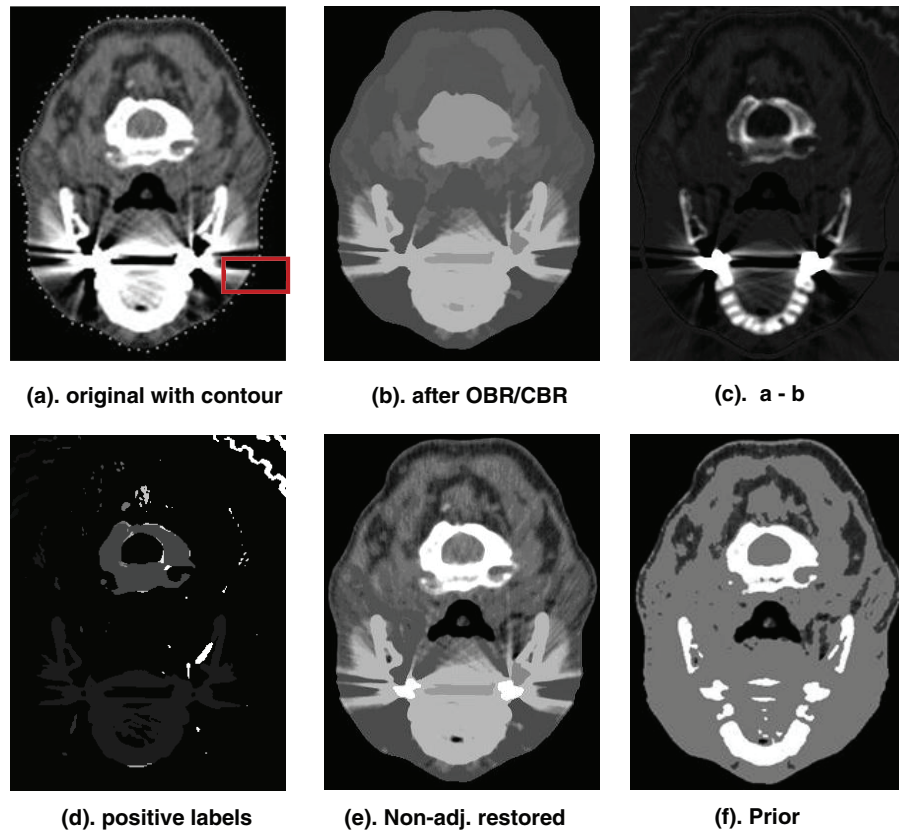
Stages in the generation of a prior image of a CT head scan. The contour is represented by the dotted line in (a), the image after CBR and OBR in (b), the difference image (a-b) in (c), labels from the positive differences are in (d), the recovery of nonadjacent labels is shown in (e), and the final prior image is in (f). WW/WL = 200/0 HU in (a), (b), (e), and (f). WW/WL 200/-1000 HU in (c).
